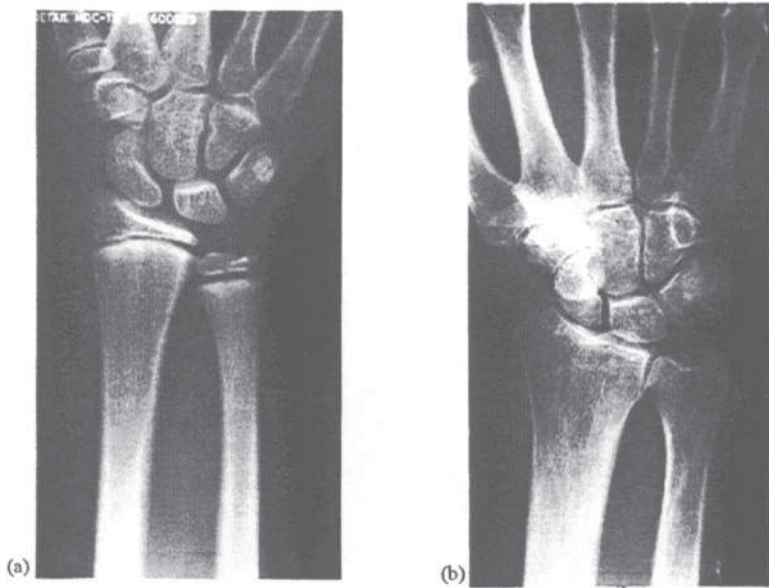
X-ray photographs of growth epiphyses showing growth plates (a) open and (b) fused
